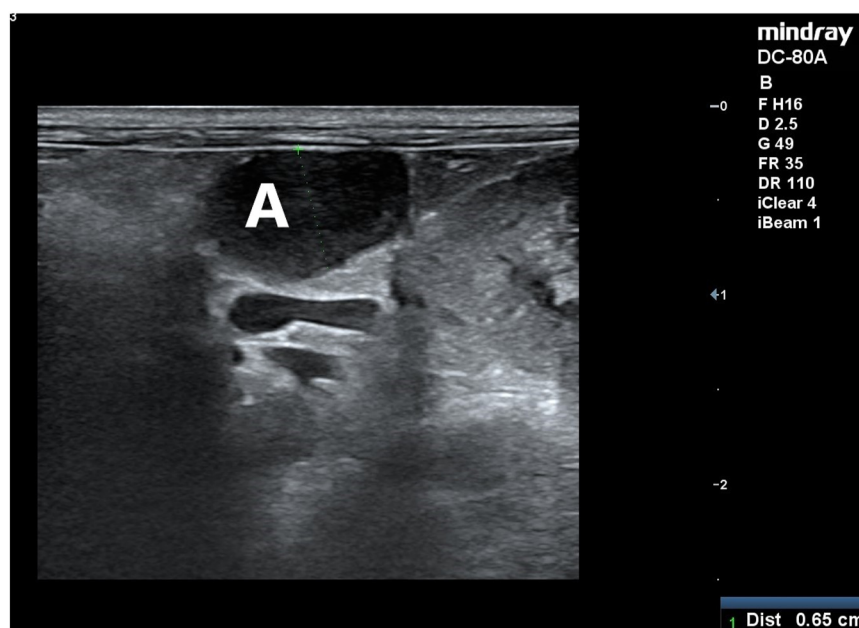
The left adrenal gland (A) was 6.5 mm on this ultrasonographic image, indicating adrenal gland hypertrophy
